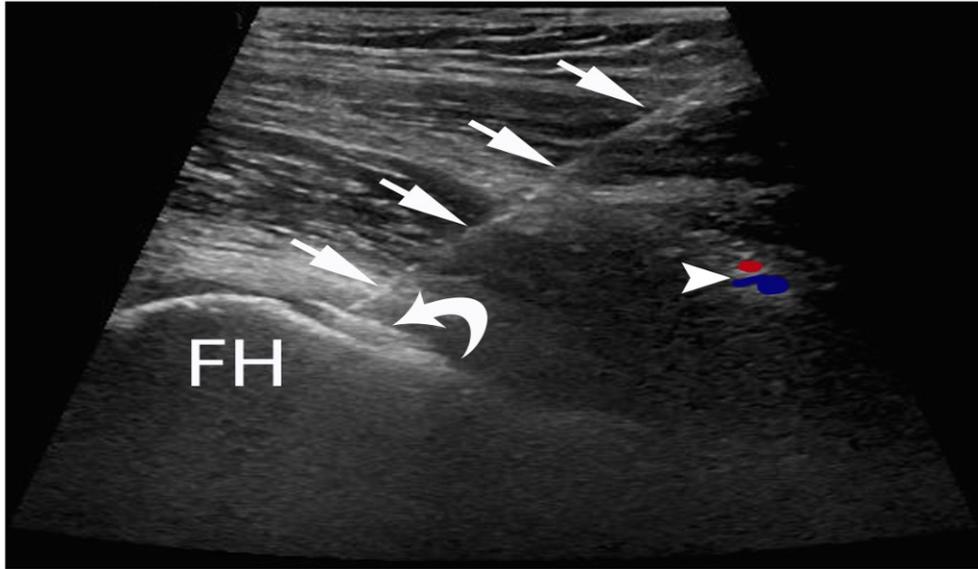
Hip injection under ultrasound guidance. Long axis view parallel to the femoral neck. Note the oblique course of the 20-gauge spinal needle (straight arrows) with the tip on the femoral head (FH). Note the steroid injectate within the hip (curved arrow). Note also the profunda femoris artery and veins (arrowhead).
